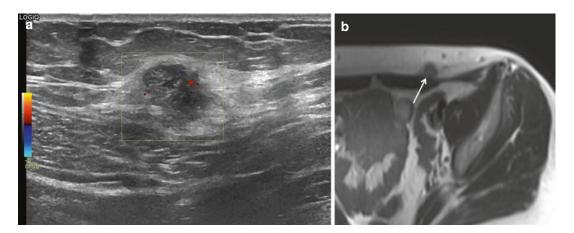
Endometrioma at the abdominal wall in 40-yearold female patient with cyclic painful small mass at the left iliac fossa and previous history of laparoscopic surgery. (a) US examination demonstrating nonhomogeneous hypoechogenic small mass lesion demonstrating small vessels, irregular margins with infiltrative aspect in the subcutaneous tissue and at the rectus abdominis fascia. (b) MRI axial haste T2-WI with nonhomogeneous low to intermediate SI mass superficially located. Note also infiltration of the superficial muscle fascia of the rectus abdominis muscle
